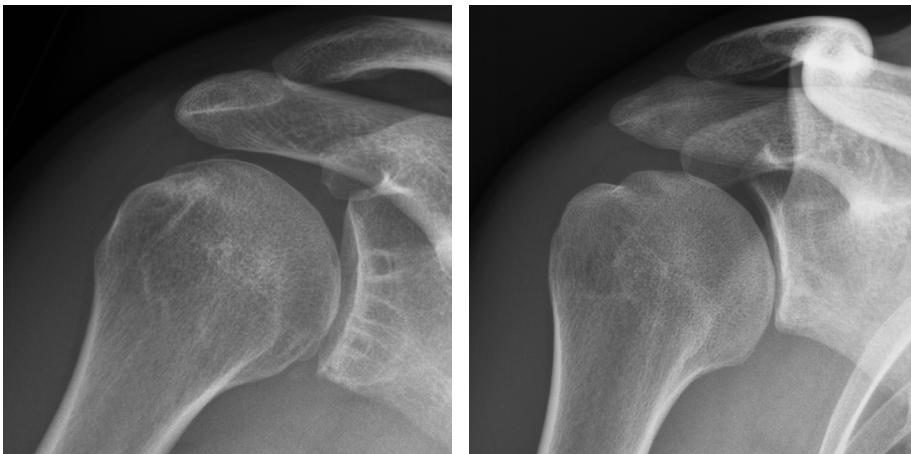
Example from radiographs: Left: Radiograph of a 24-year-old male seven years after the index procedure, where dislocation arthropathy is classified as mild and the drill-hole appearance is classified as visible with cystic changes. Right: Radiograph of a 26-year-old male seven years after the index procedure, where dislocation arthropathy is classified as moderate and the drill-hole appearance is classified as hardly visible*
